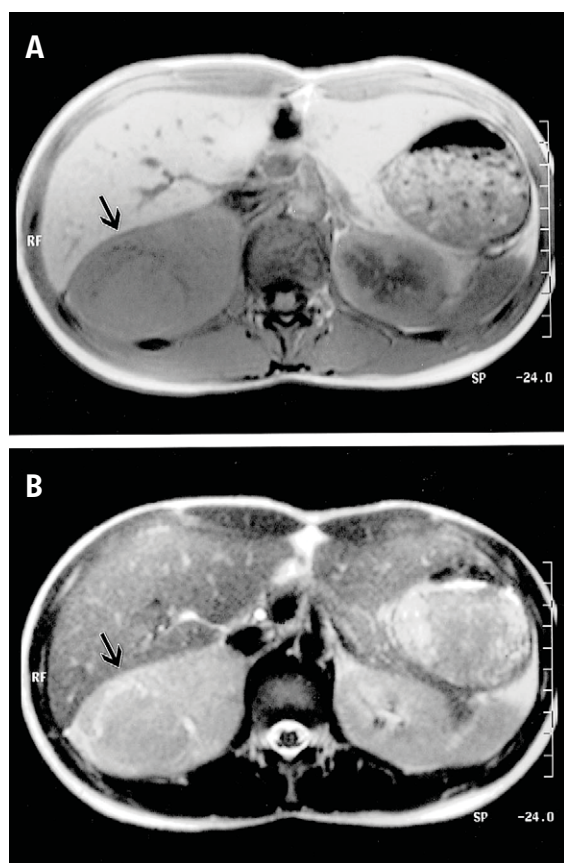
Magnetic resonance imaging of the adrenal glands shows an oval-shaped multicystic tumor, 9 × 5 × 8.4 cm in size, in the right suprarenal region. The tumor shows: (A) low signal intensity on T1-weighted scan (arrow); and (B) mild enhancement on T2-weighted scan (arrow).
